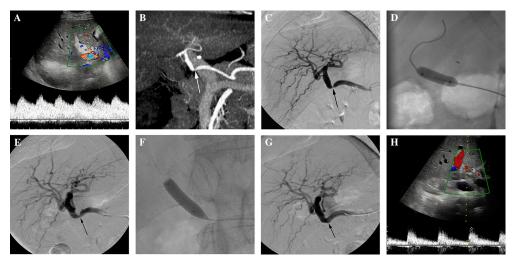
Endovascular treatment of an anastomotic stenosis of the hepatic artery in a 62-year-old transplanted patient. A Doppler-US of the donor hepatic artery showing a tardus-parvus waveform (resistive index, 0.39; time to peak, 0.22 s). B Coronal MIP CT image showing a short anastomotic stenosis (arrow). C Hepatic angiogram confirming a short stenosis > 70%. D Angioplasty with a 5-mm balloon.
